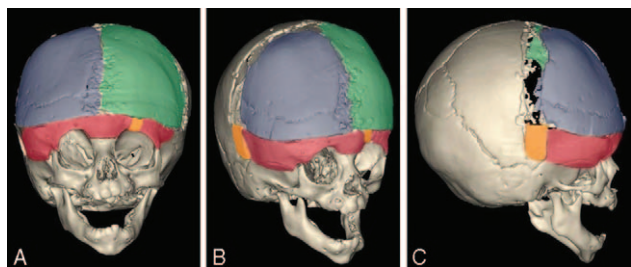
Postoperative computed tomography scan showing the authors' operative approach, specifically the placement of an interpositional bone graft in the contralateral orbit. (A) Anteroposterior view. (B) Oblique view. (C) Lateral view.
